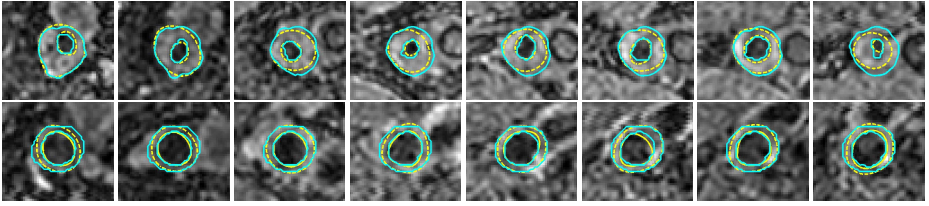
Slice-wise comparison of the computation results (cyan) to the manual segmentation (yellow) for the femoral wall and lumen boundaries for three 3D MR images
